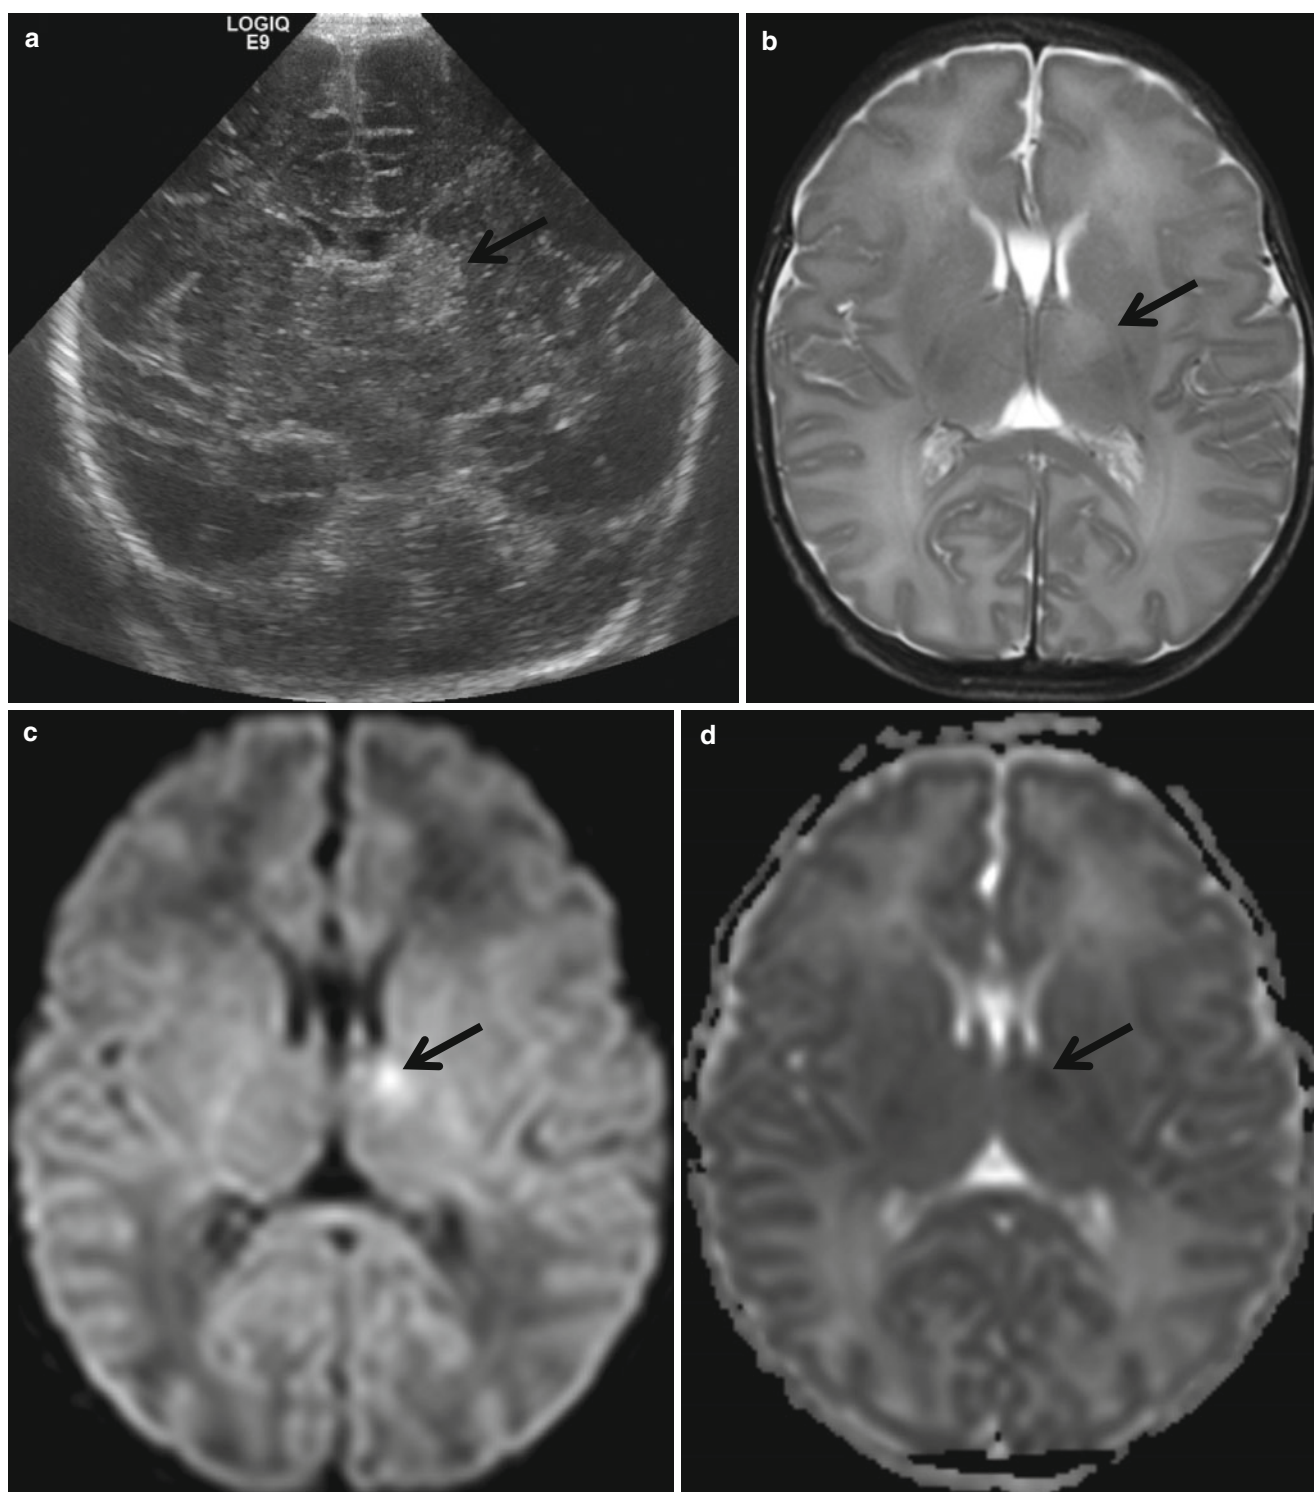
Focal thalamic infarct in a neonate. (a) Coronal sonogram shows small echogenic area at the left thalamus (arrow). (b) T2-weighted image obtained the same day shows subtle high signal
